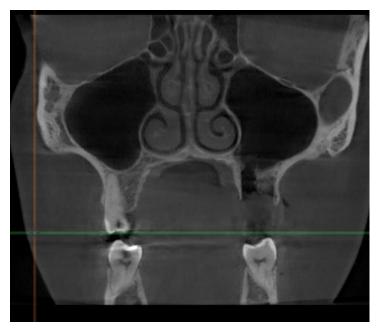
A CBCT image in the coronal section before the procedure, showing the sinus perforation at the palatal root.
